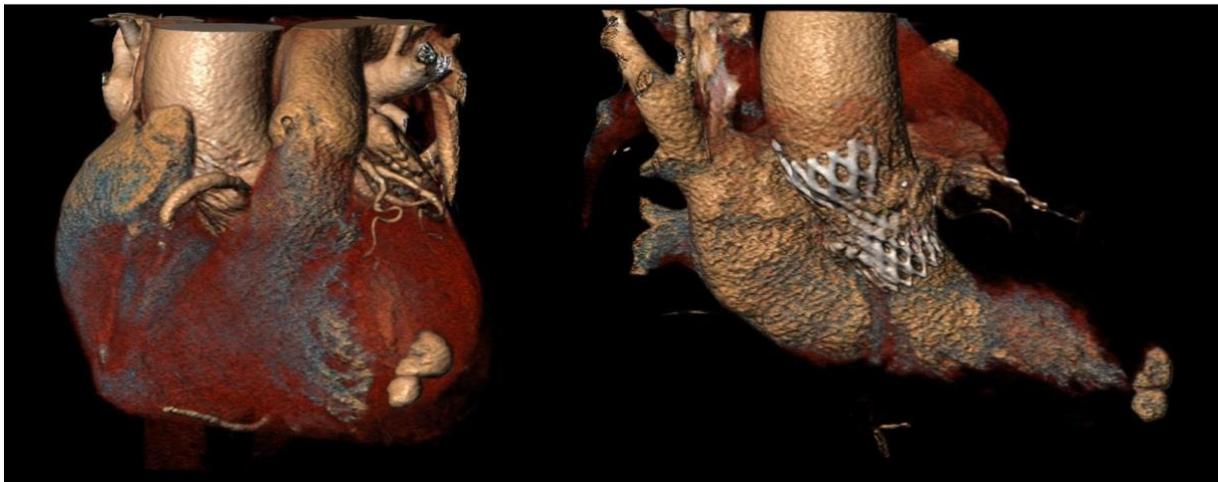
The preoperative examination and CT visualization of the left ventricle reveals a narrow lumen
